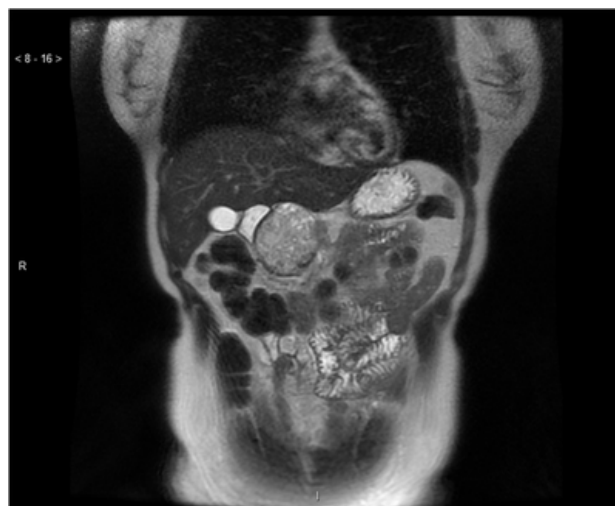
Abdominal magnetic resonance imaging showed similar characteristics of a large and complex mass pancreatic head topography.
